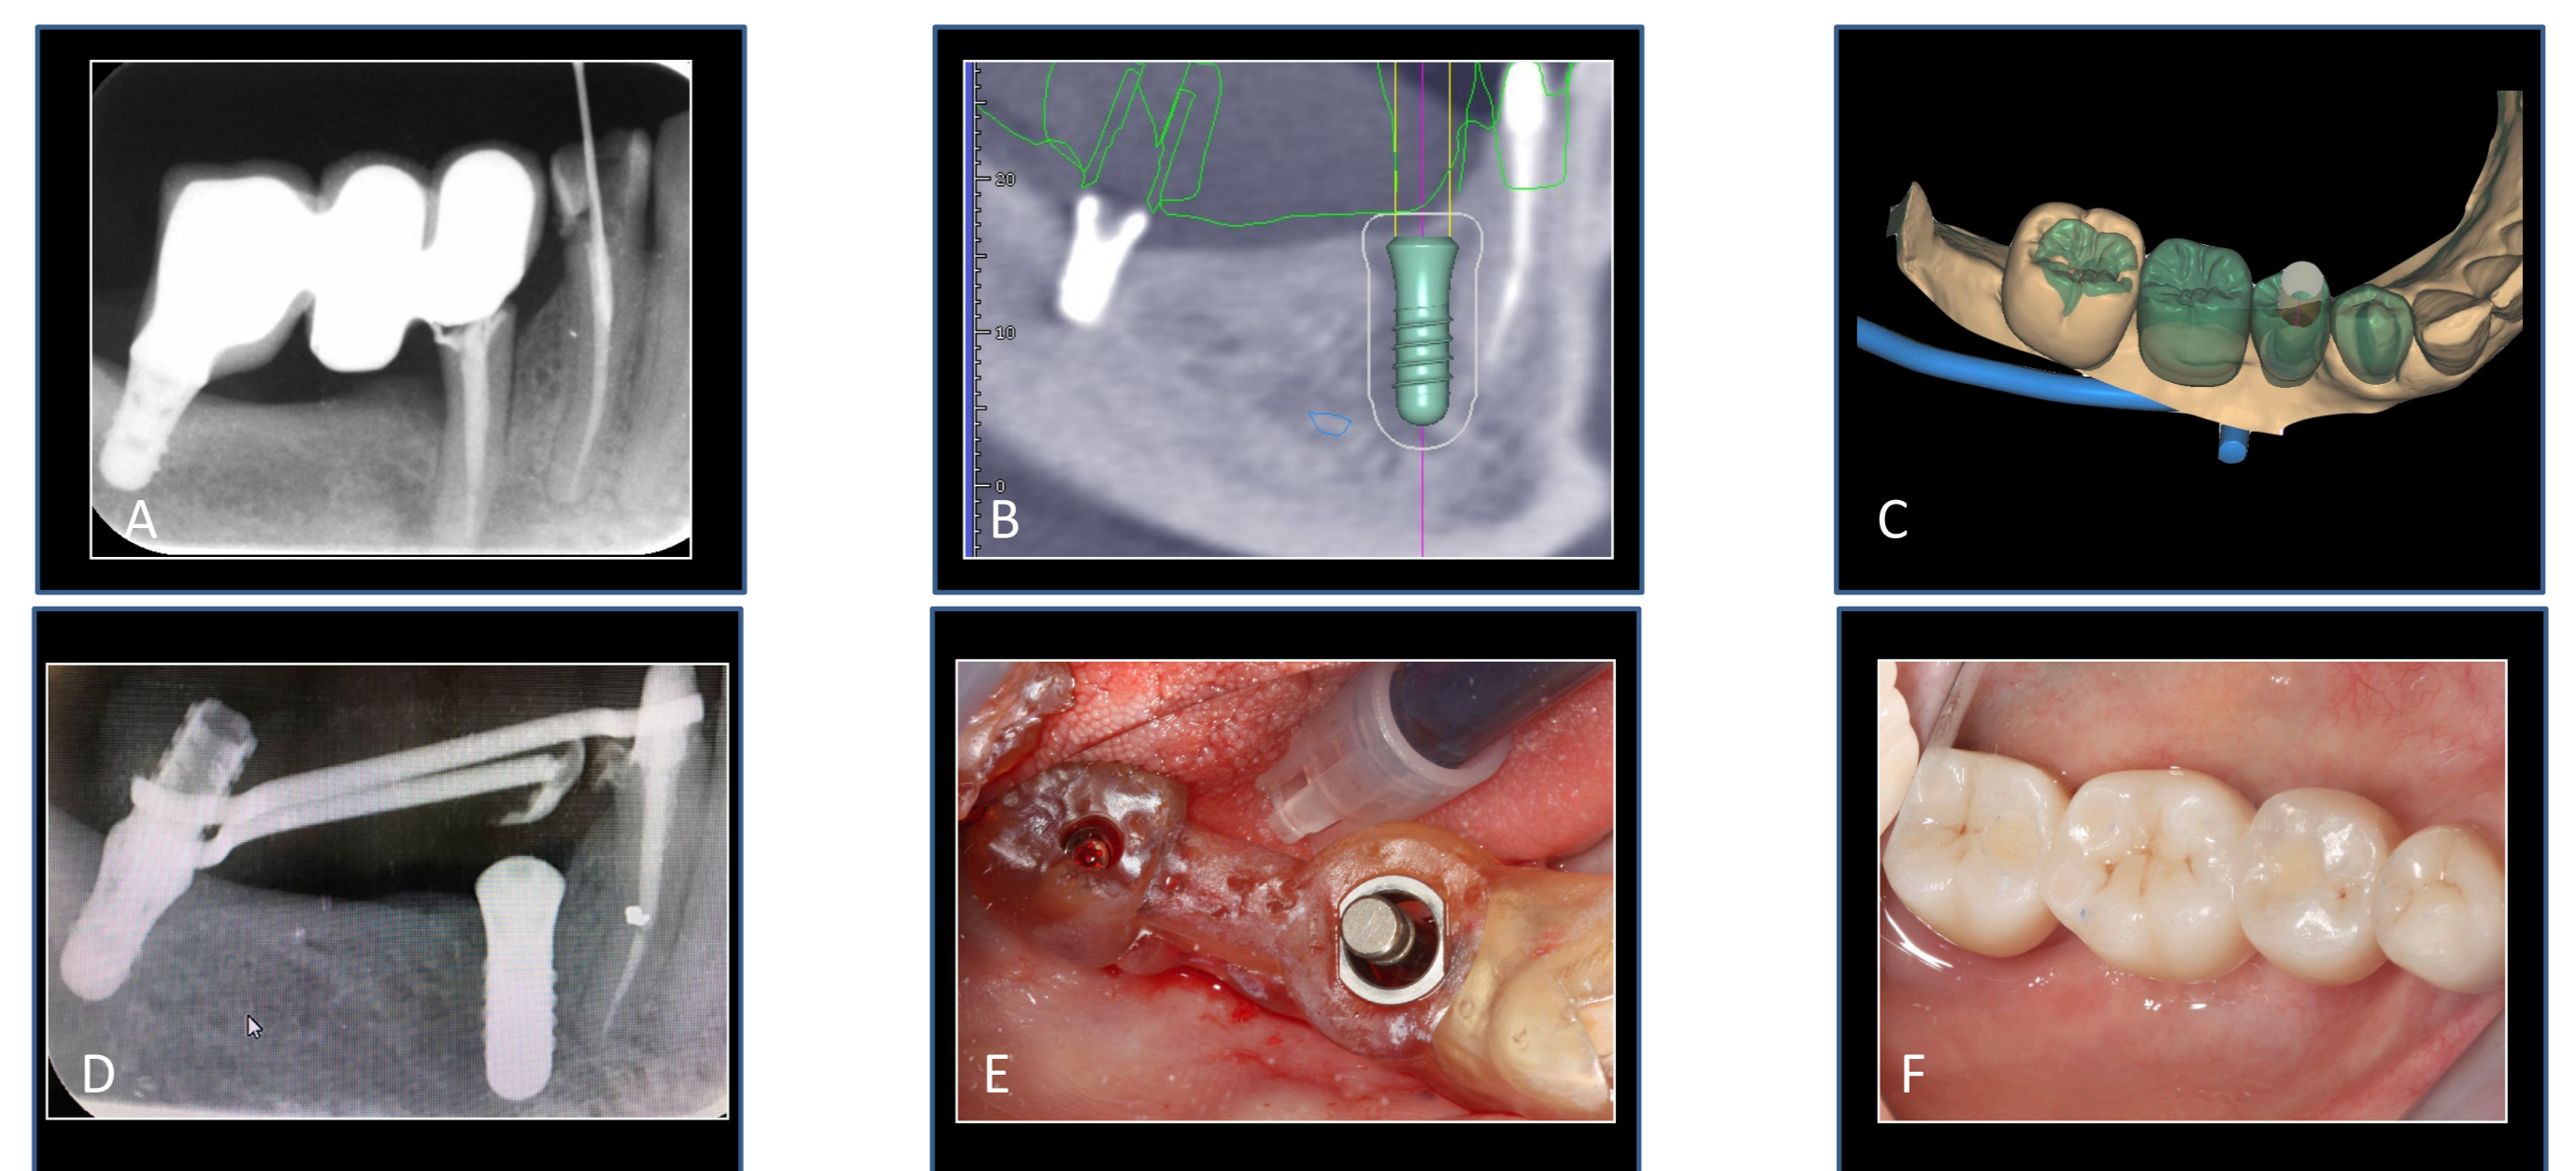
A) Failing tooth implant bridge, B) Virtual implant planning, C) Wax-up, D) Periapical radiography after implant placement, E) Intra-oral views of screw retained guide for implant placement, F) final implant bridge work
